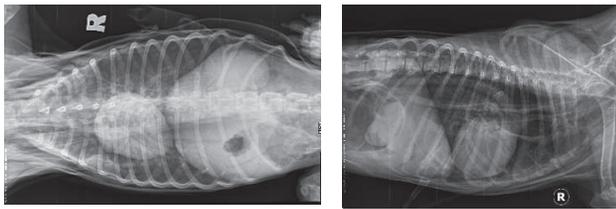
Pneumothorax - thoracostomy tube connected at Heimlich valve (radiographic views)
